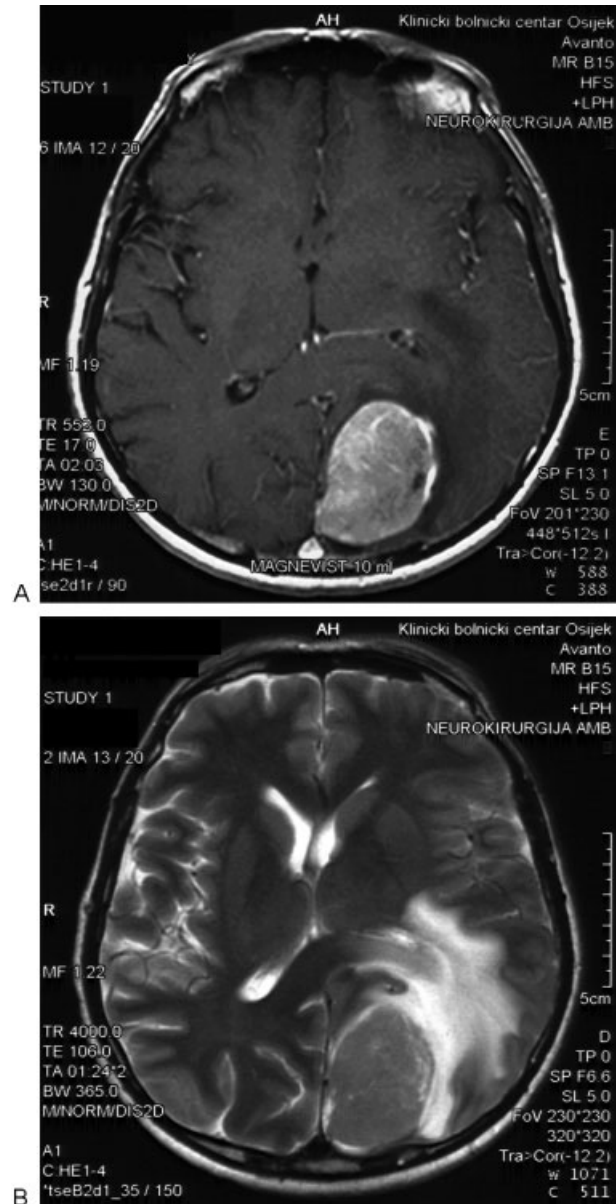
(A) Preoperative T1-weighted axial magnetic resonance imaging (MRI) showed a well-delineated hyperintense, intensively contrast-enhancing tumor adjacent to the superior sagittal sinus and with a compressive effect onto surrounding brain parenchyma resembling a meningioma or a melanin-infested tumor. (B) Preoperative T2-weighted MRI revealed a homogeneous hypointense tumor localized in the left occipital lobe.
